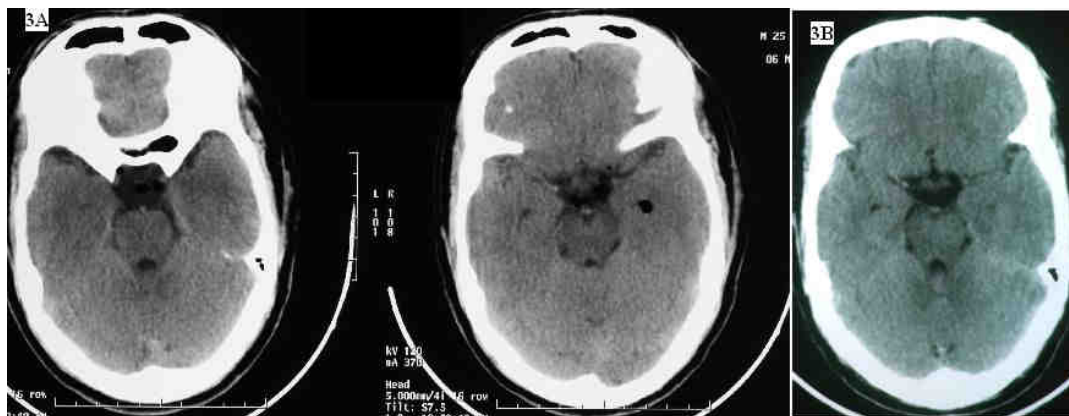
Initial Axial plain CT head revealing pneumocephalus with presence of air in basal cistern and left temporal horn of lateral ventricle(3a) and repeat CT scan of head on 7th day showed resolved pneumocephalus(3b)
